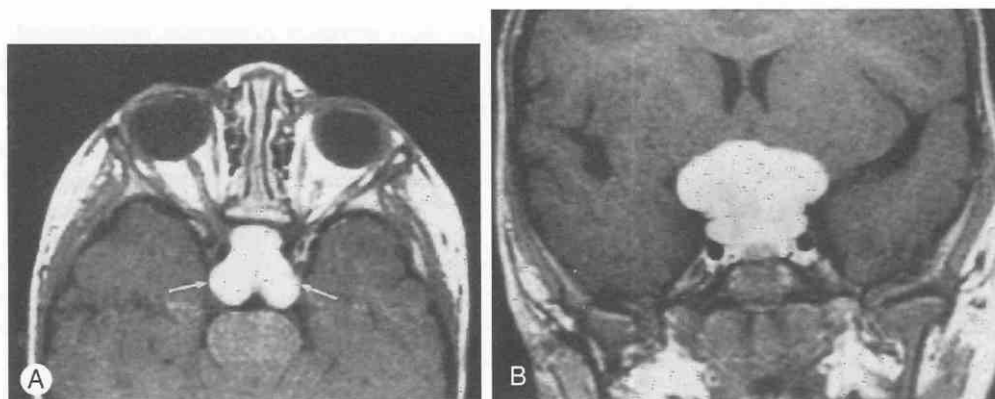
A, T1-weighted axial MRI study with gadolinium enhancement shows optic glioma of the optic chiasm (arrows). B, T1-weighted coronal MRI study with gadolinium shows same patient as in A.
